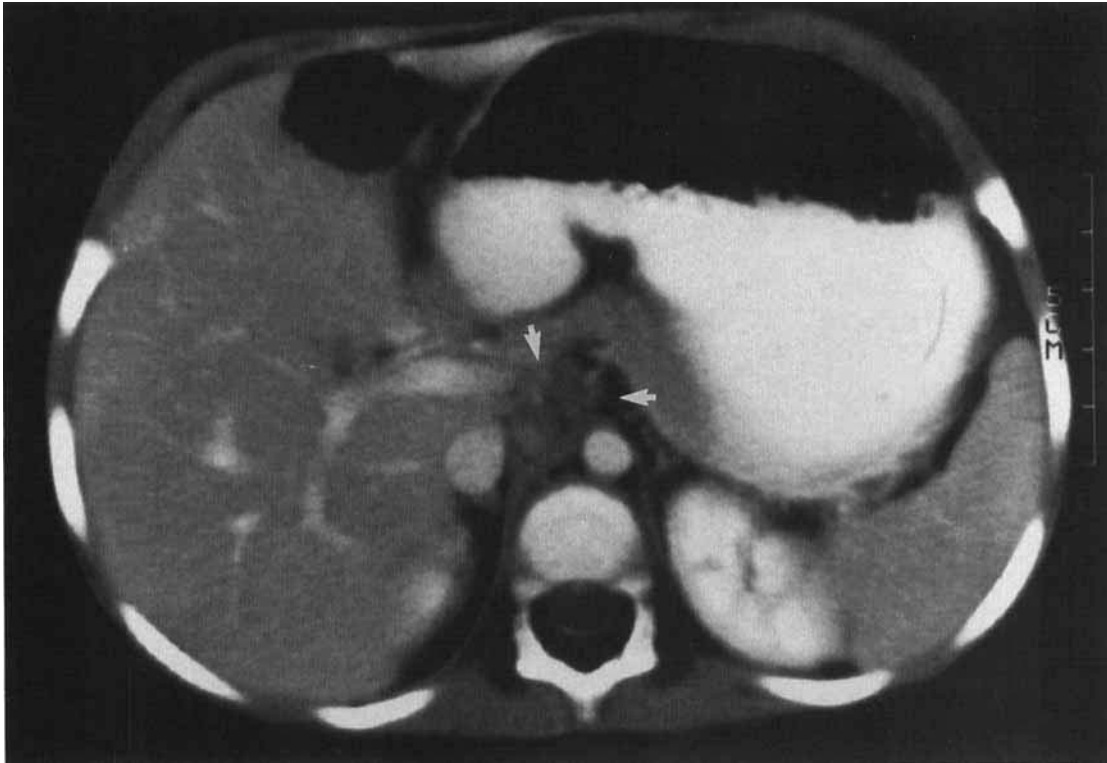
Abdominal CT. The arrows point to a small mass in the portacaval space.
